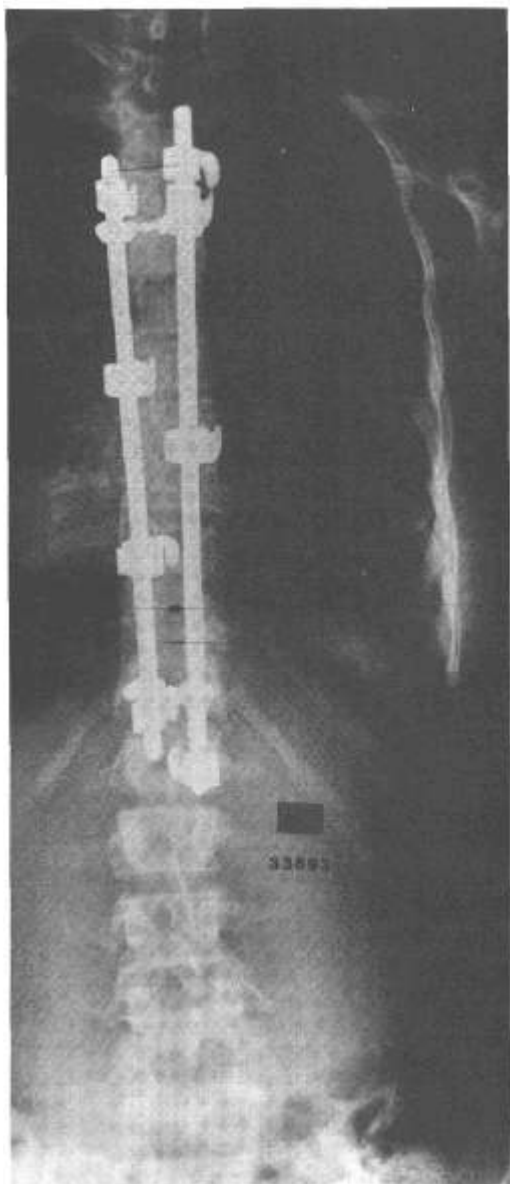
Initial standing postoperative AP roentgenogram.
